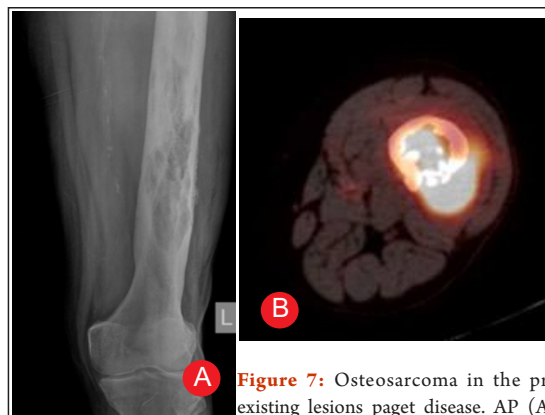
Osteosarcoma in the pre-existing lesions paget disease. AP (A) radiographs shows thickened trabeculated femoral diaphysis. (B) Axial image of the PET-CT shows cortical break with soft tissue which shows intense uptake of FDG.
